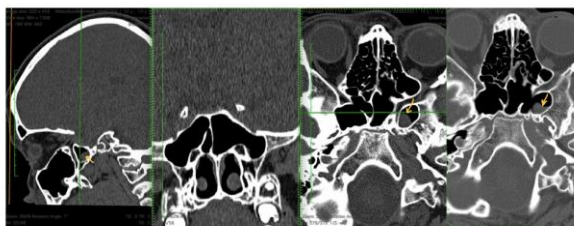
postoperative CT. 40 days post-operative CT shows near total drainage of the left sphenothmoidal sinus with small remaining mucocoele (arrow) within the left ethmoidal sinus.
